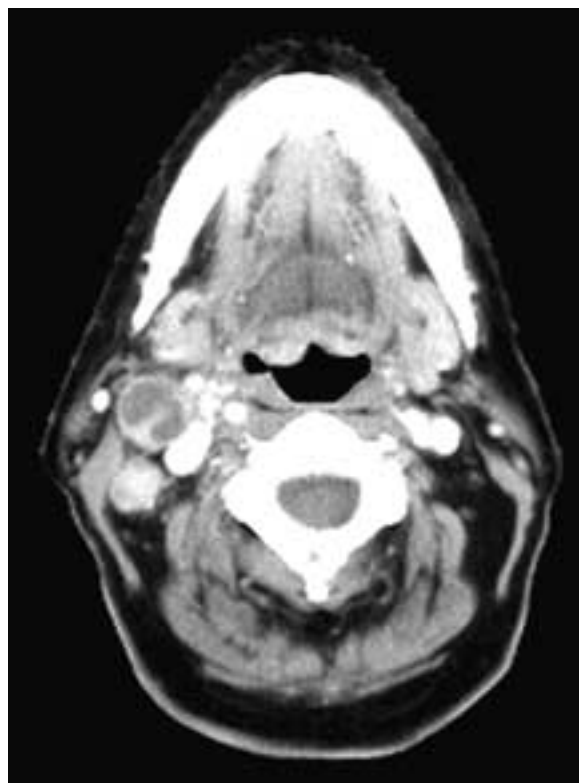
Axial contrast-enhanced CT scan shows two right level II lymph nodes. The more anterior node is enlarged and necrotic, with an irregular, enhancing rim. There is no gross extranodal tumor spread. The second node is enhancing, but normal by the size criterion. This patient had a right oropharyngeal carcinoma, and both of these nodes were metastatic.
